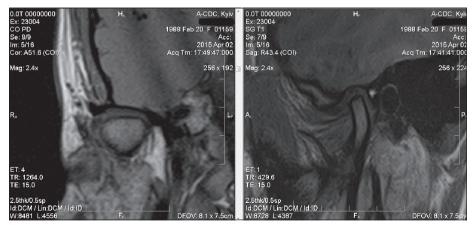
MRI of TMJ. Frontal (left side) and – sagittal (right side) views.
